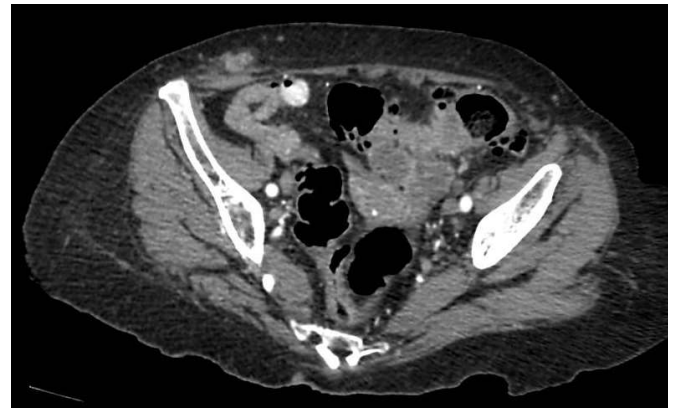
Abdominal CT scan with metastatic disease.
